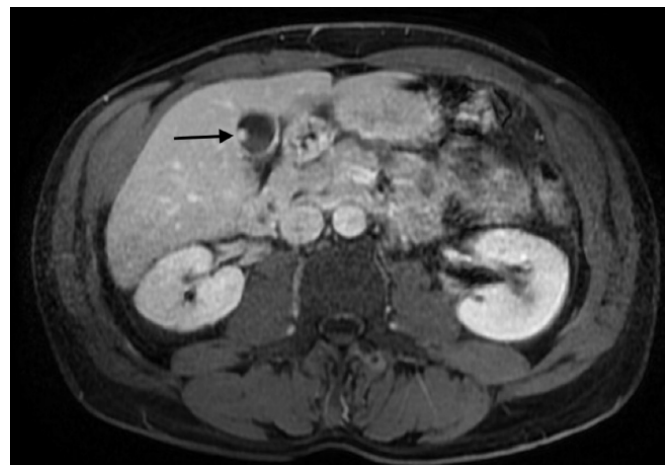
MRI with contrast with MRCP Findings: Non-calcified soft tissue mass arising from the anterior wall of the gallbladder. Published with Permission
